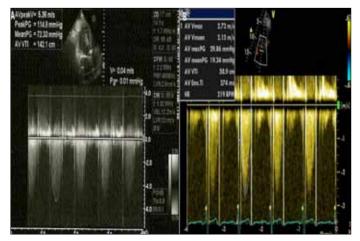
Doppler echocardiographic views of aortic gradients: A-during the valve thrombosis, B-after coronary embolism
